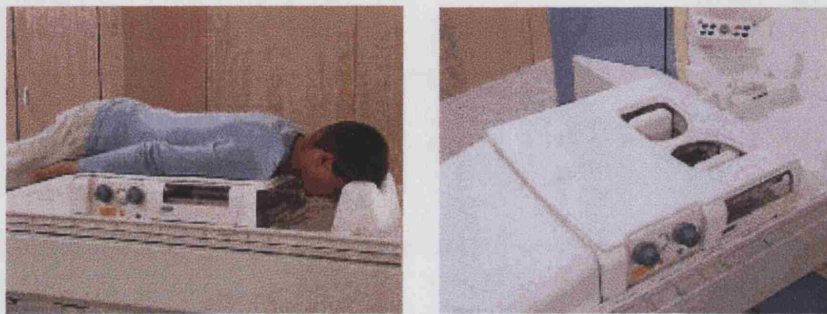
A photograph of a breast array coil (Seimens Medical) for MRI breast examinations (website 1).
